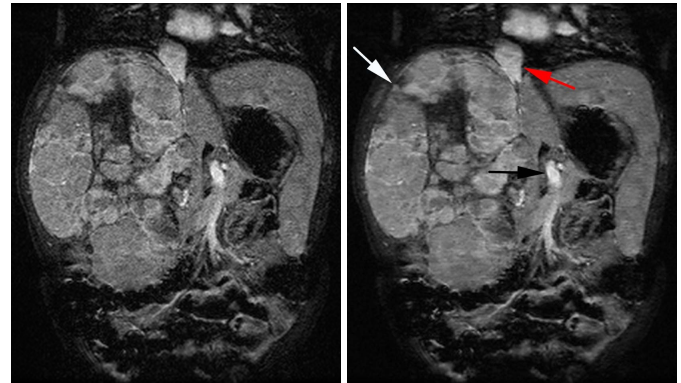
Slice from an 8-channel abdominal MRI of an 8-month old patient, reconstructed using both a GE ARC PI product (left) and our L1-SPIRiT algorithm (right), which ran in 97 seconds. A hepatoblastoma (white arrow) abuts and compresses the inferior vena cava (red arrow). Note the superior mesenteric vessels (black arrow).
